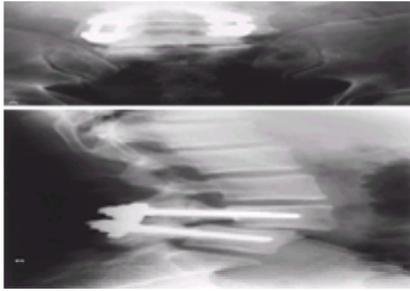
Anteroposterior (A) and lateral (B) radiographs of a fusion with screws and plates.
